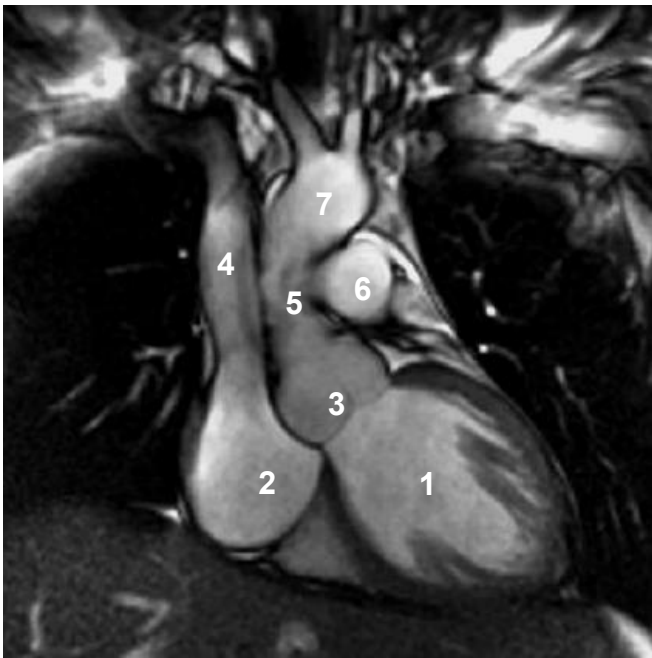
MRI of the heart. Anatomy of the heart from an oblique front view.
